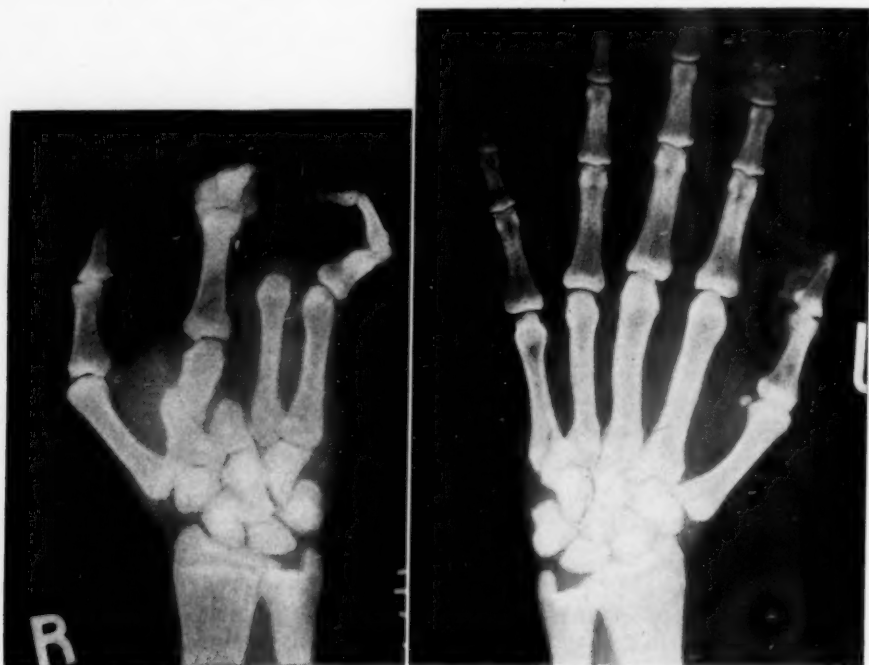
Roentgenograms of the hands.
